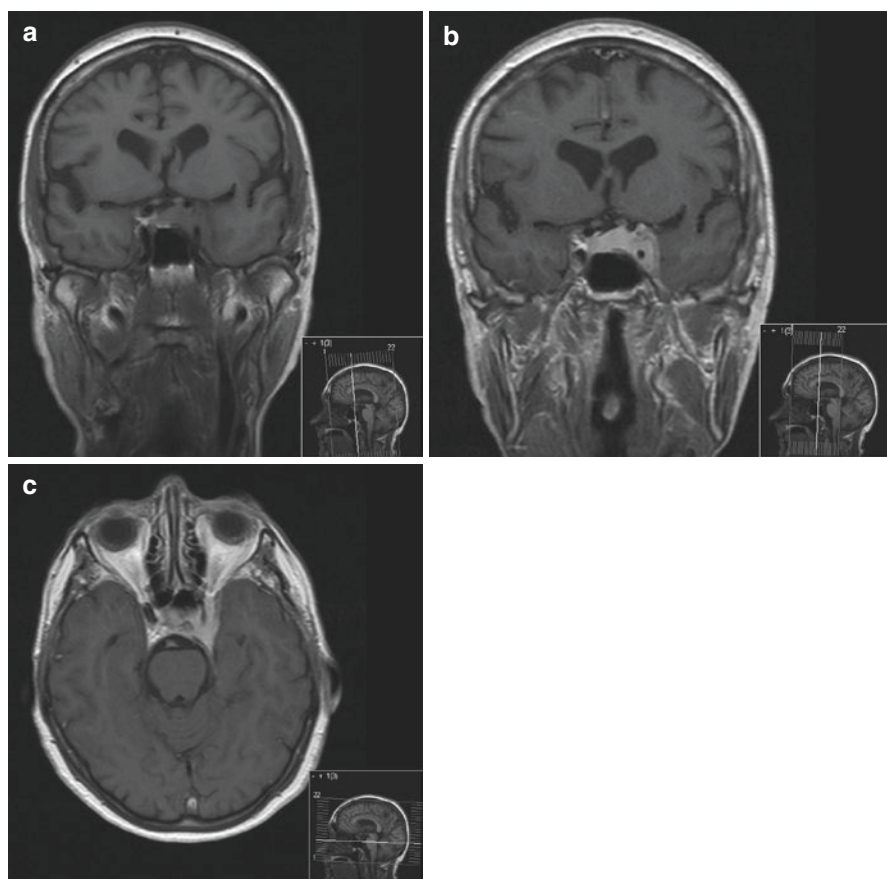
T1 weighted coronal MRI (a) before and (b) after administration of contrast showing a homogeneous well-circumscribed mass arising from the left cavernous sinus, extending to the suprasellar cistern superiorly and the orbital apex anteriorly. The lesion enhances vividly (b, c) and is typical of a meningioma
